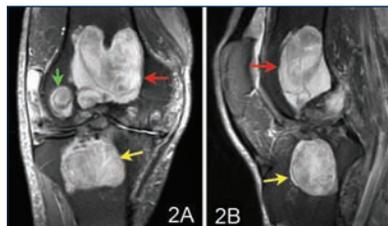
Coronal (2A) and sagittal (2B) T2 MRI images, demonstrating large lateral femoral condylar (green arrow), intercondylar (red arrow), and proximal tibial (yellow arrow) cysts.
